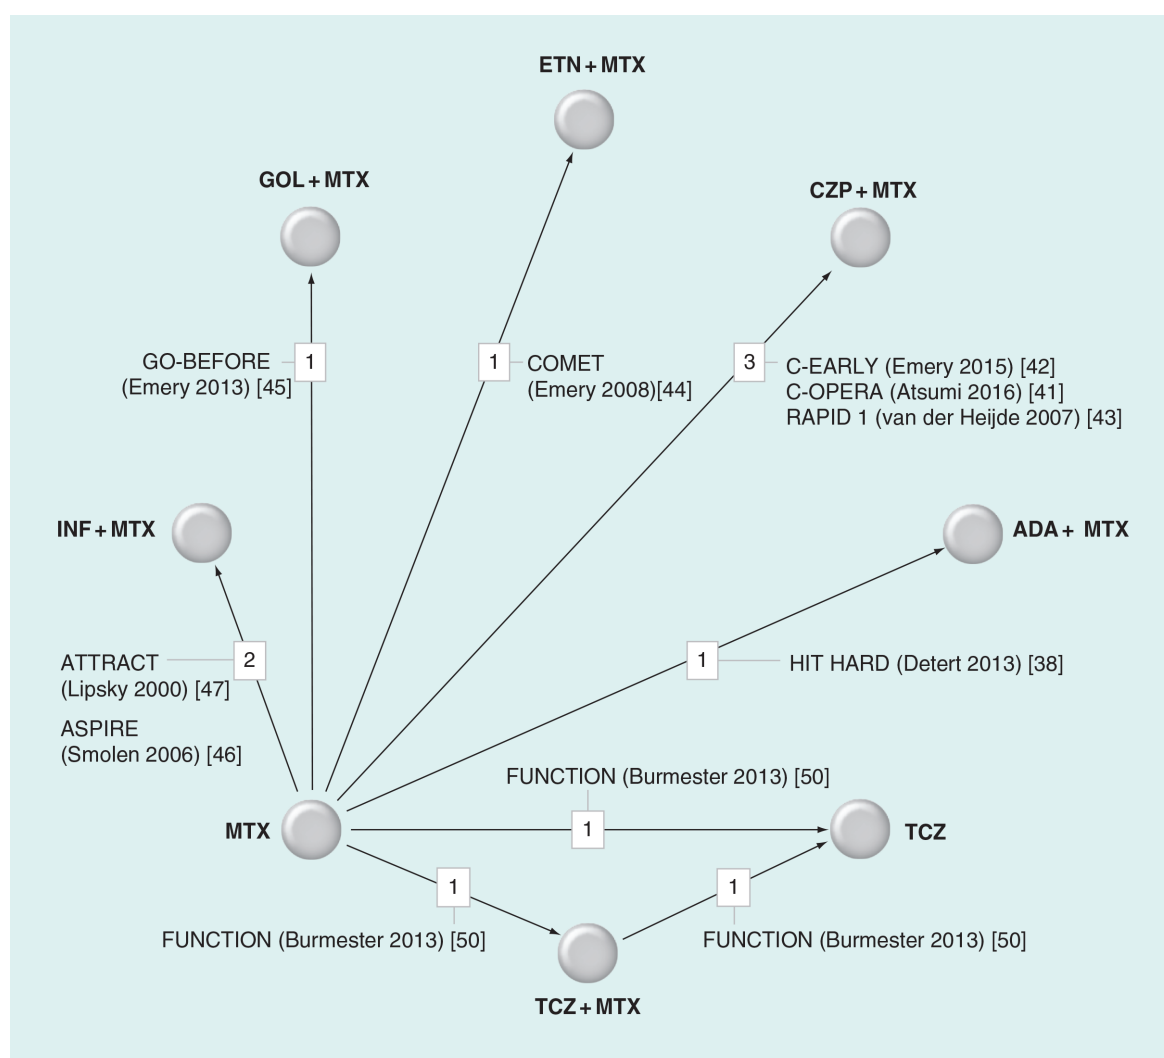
Network of nine base case studies evaluating the effect of biologics on radiographic progression in rheumatoid arthritis at 1 year.
